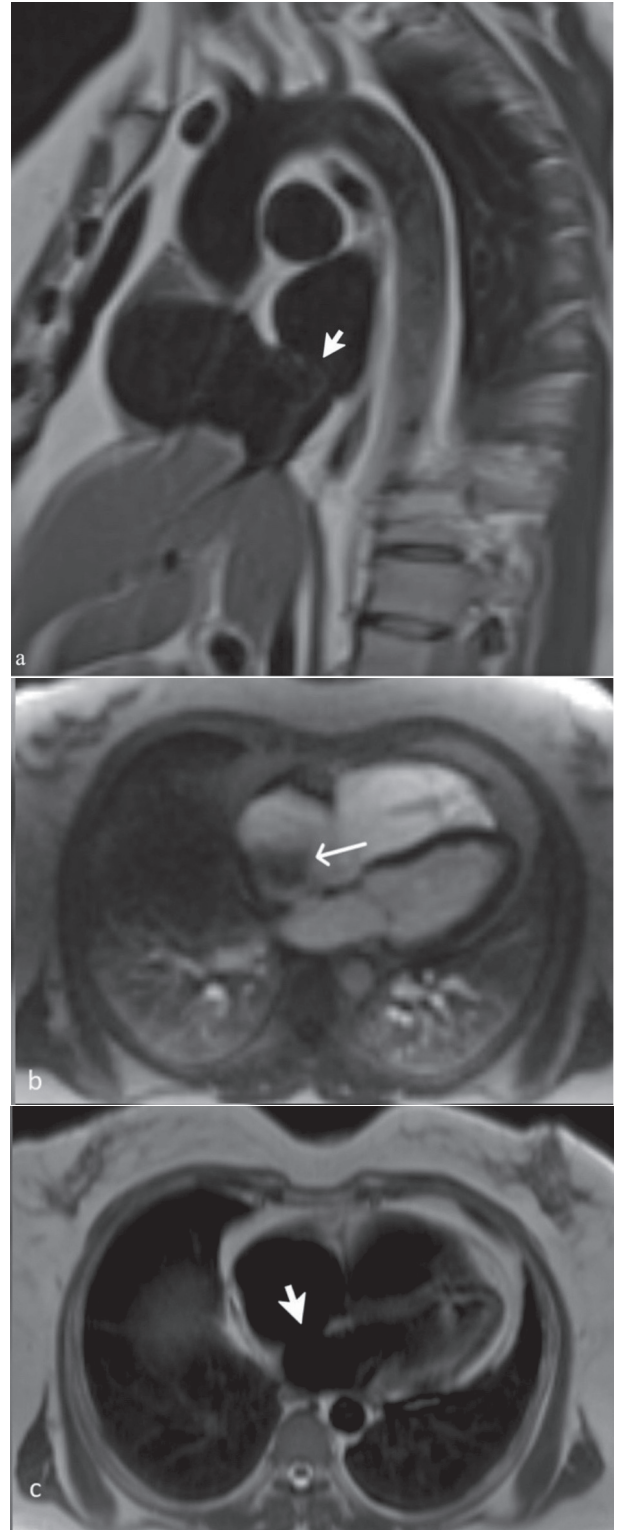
In a 23-year-old female case, parasagittal T1-weighted (a) and the fourth chamber HASTE (c) images show a large ASD (arrow) up to 25 mm in size. Right-to-left shunt flow (thin arrow) is observed in 4-chamber imaging in perfusion examination (b)
